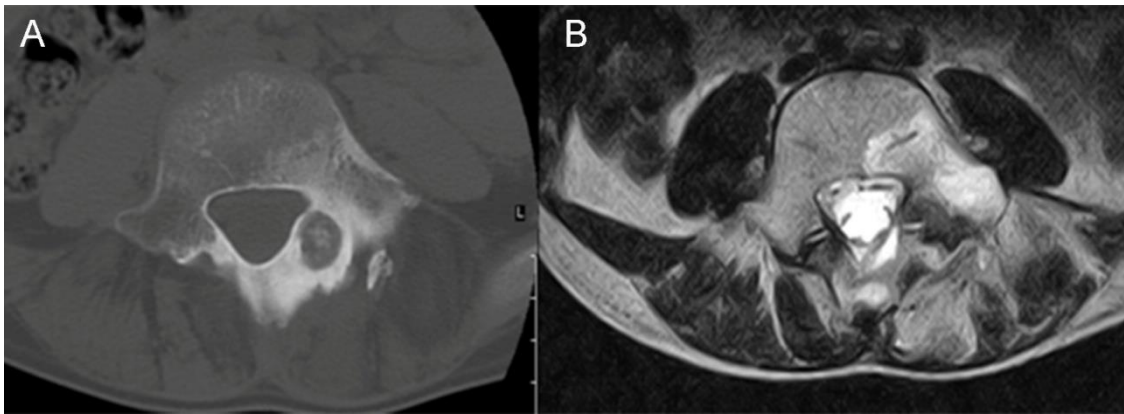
Osteoid osteoma of the posterior elements of the spine, A. axial CT image, B. axial MRI image (T2 sequence)
